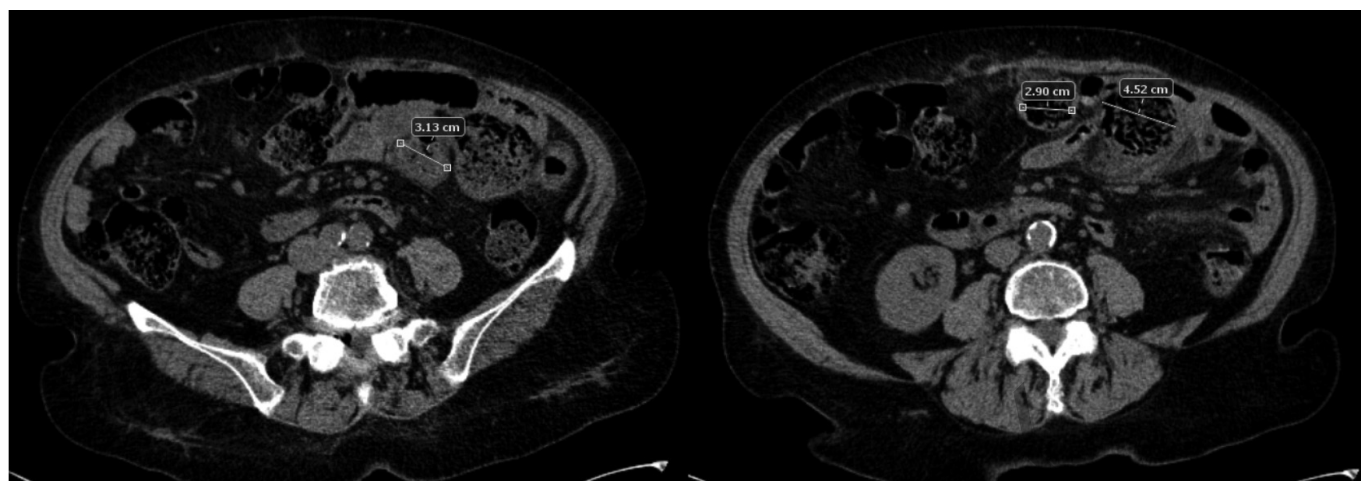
Abdominal CT scan demonstrated three round lesions containing faecal-like material mixed with gas (3.1 cm, 2.9 cm, 4.5 cm) within the mesentery, in the left side of abdomen. These lesions were seemed to communicate directly with adjacent loops of small bowel with a surrounding inflammatory reaction in peritoneum.
